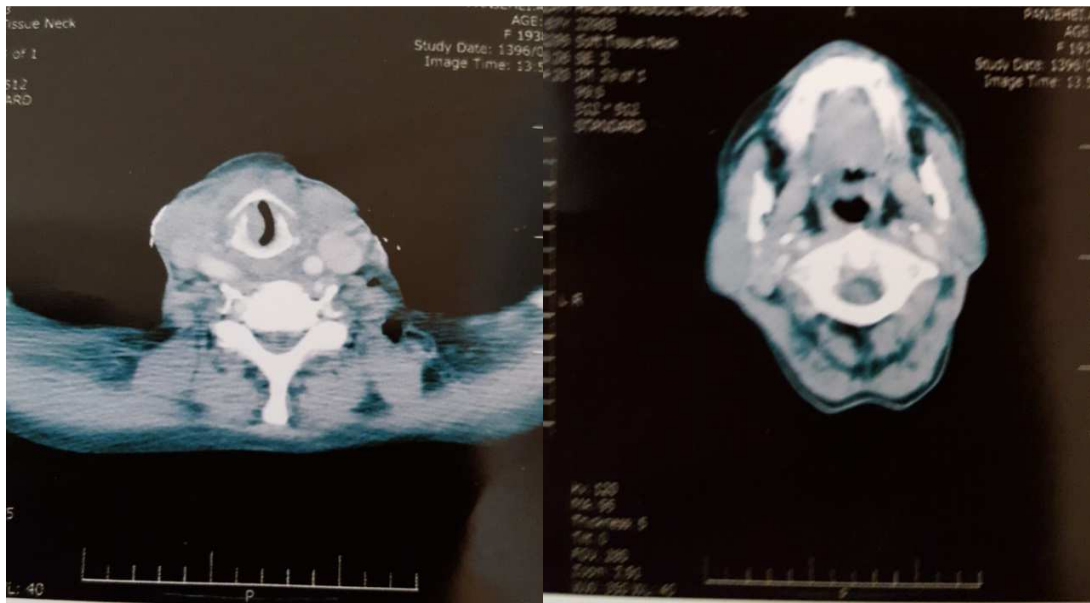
CT scan, diffuse FVC and aryepiglottic folds swelling
